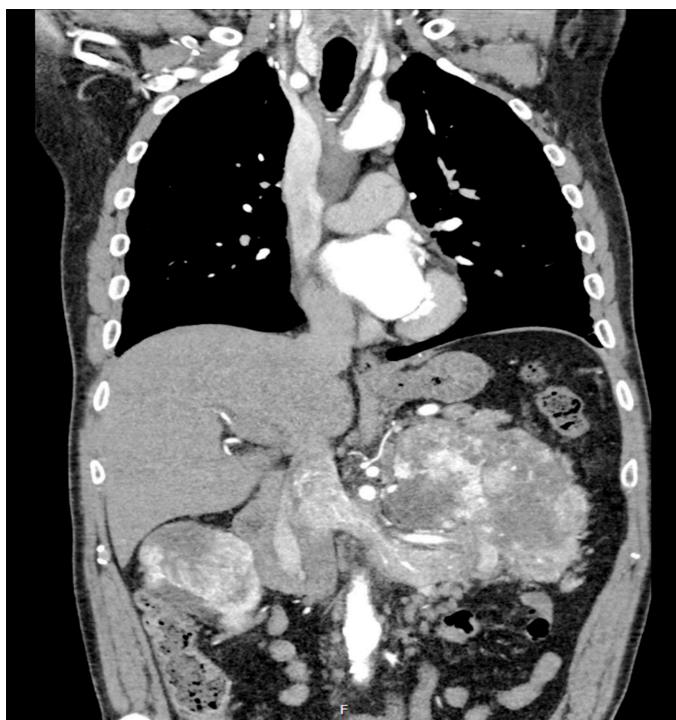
Coronal cross-section from arterial phase CT demonstrating renal vein and inferior vena cava tumour thrombus from left renal mass
